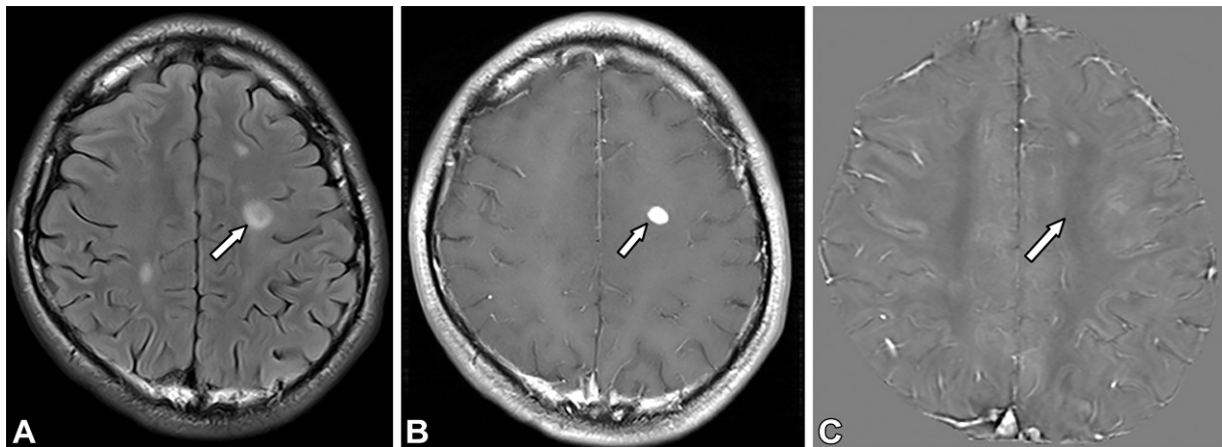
Multiple sclerosis in a 28-year-old woman with mild numbness in the right side of the body. (A, B) Axial fluid-attenuated inversion recovery (FLAIR) (A) and GBCA-enhanced T1-weighted (B) MR images show hyperintensity (arrow) in the left frontal lobe, indicating acute demyelination. (C) Axial QSM image shows no increase in the magnetic susceptibility of the lesion (arrow).
